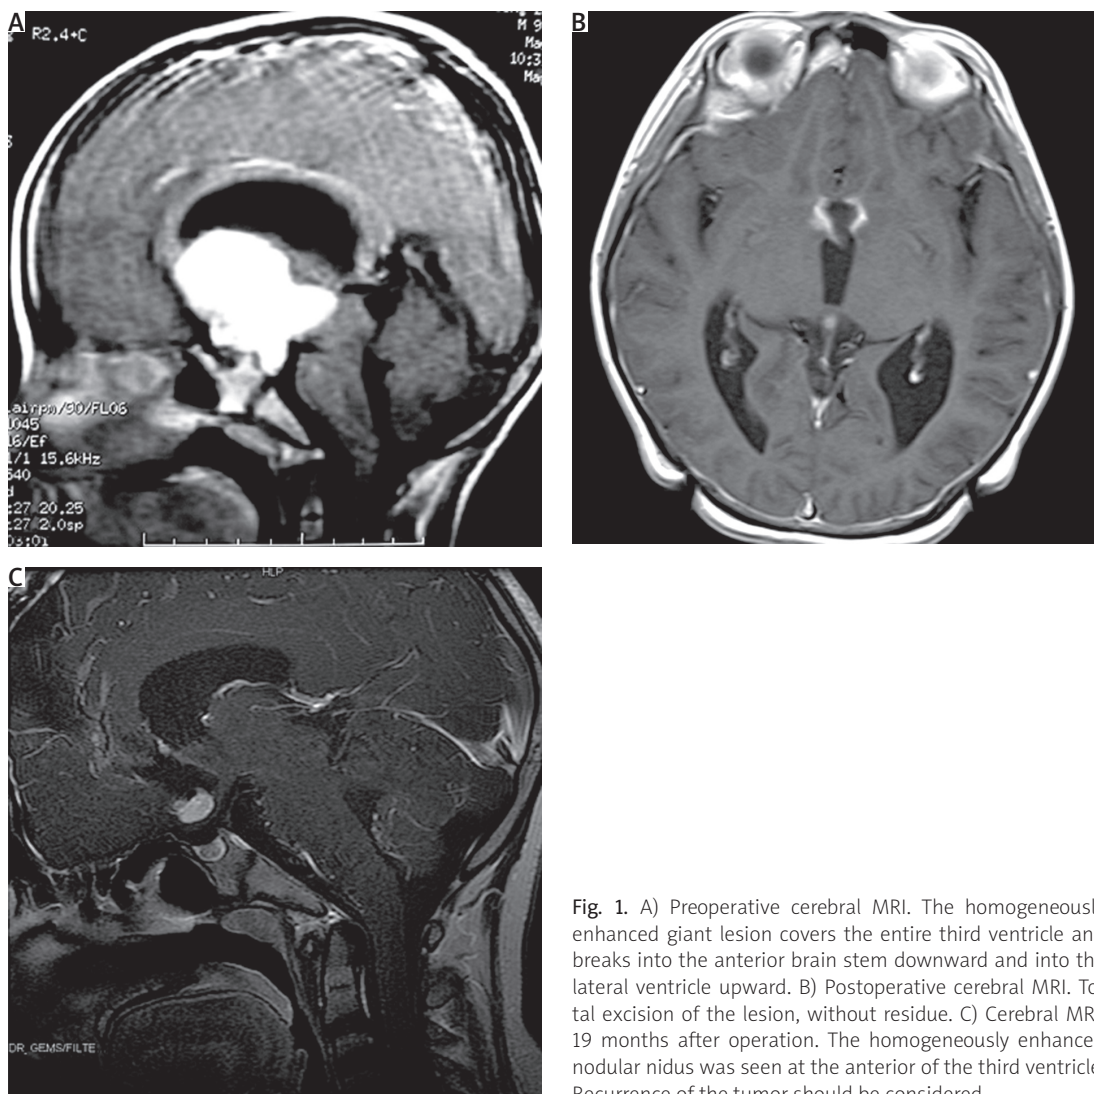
A) Preoperative cerebral MRI. The homogeneously enhanced giant lesion covers the entire third ventricle and breaks into the anterior brain stem downward and into the lateral ventricle upward. B) Postoperative cerebral MRI. Total excision of the lesion, without residue. C) Cerebral MRI, 19 months after operation. The homogeneously enhanced nodular nidus was seen at the anterior of the third ventricle. Recurrence of the tumor should be considered
